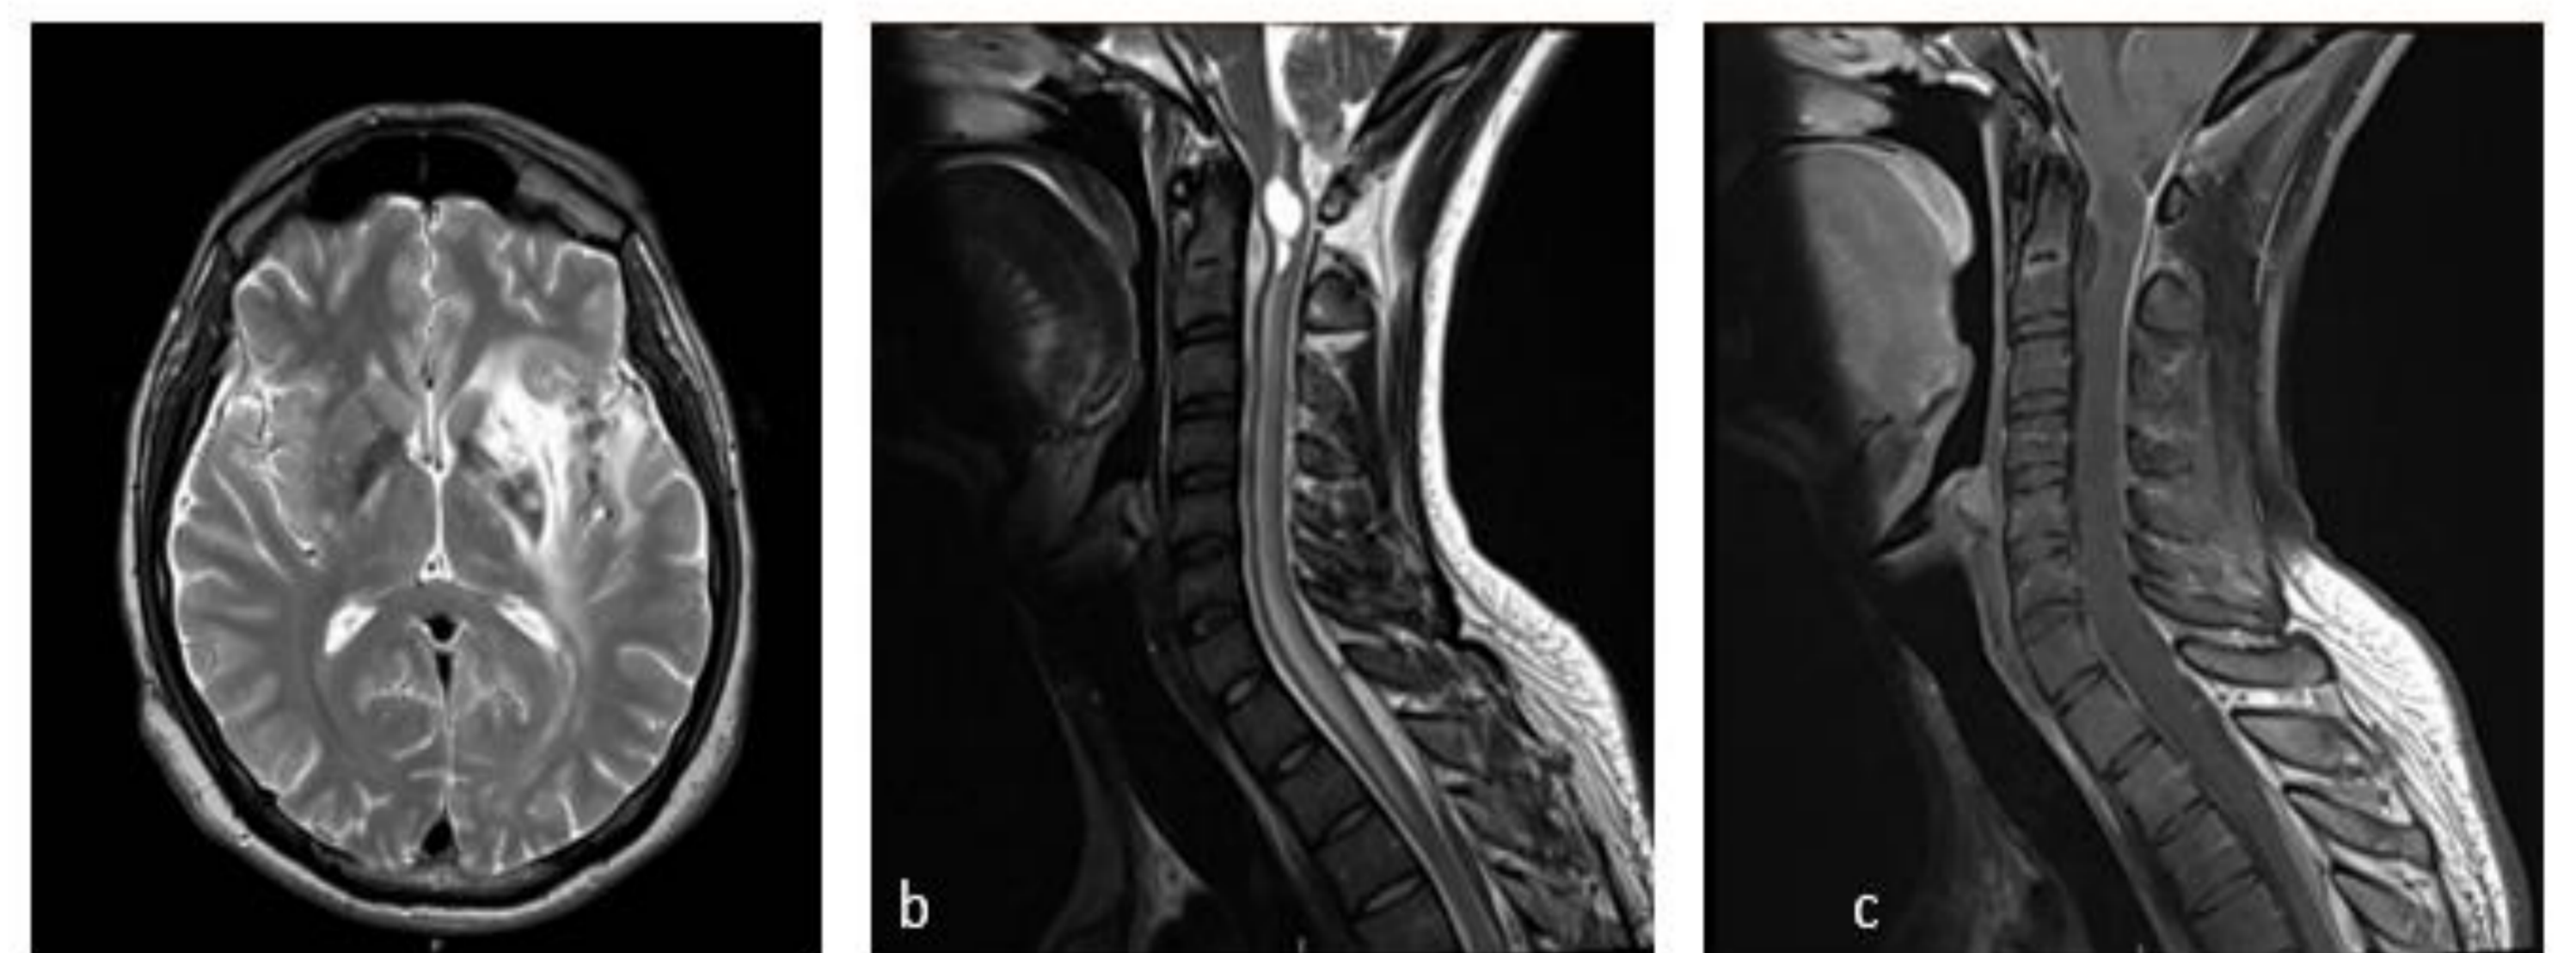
Case 1. Axial FLAIR weighted brain MRI showing bilateral diencephalic hyperintensities (a) with diffusion restriction on DWI(b) and longitudinally extense transverse myelitis on sagittal T2 weighted cervical MRI (c). Images (d-f) shows improvement after treatment with corticosteroids.
